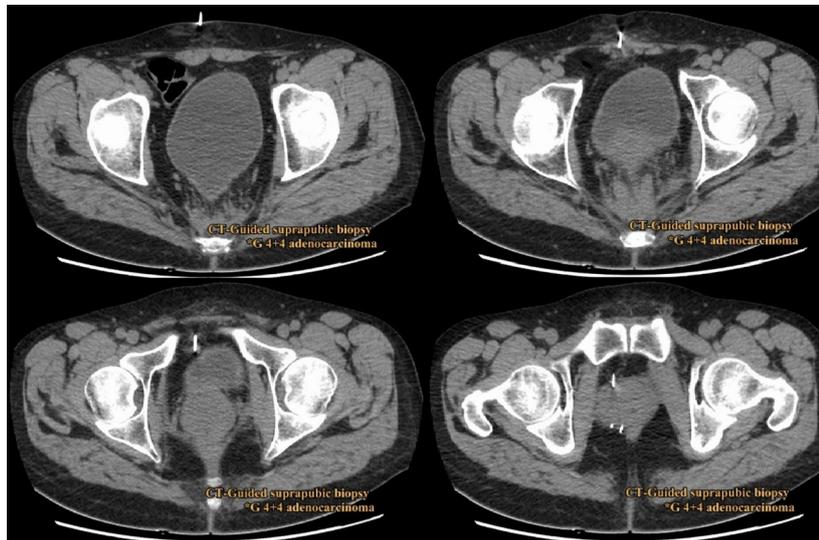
CT-Guided suprapubic biopsy was done due to closed anal verge secondary to previous surgery.
